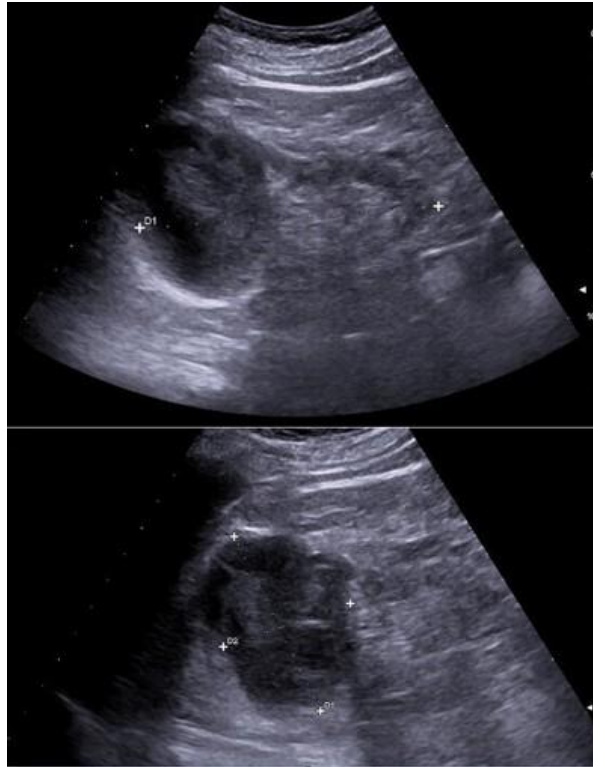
The left renal formation, previously seen on CT, with its corpuscular/pseudo-solid echogenic material is showed in B-mode US.
